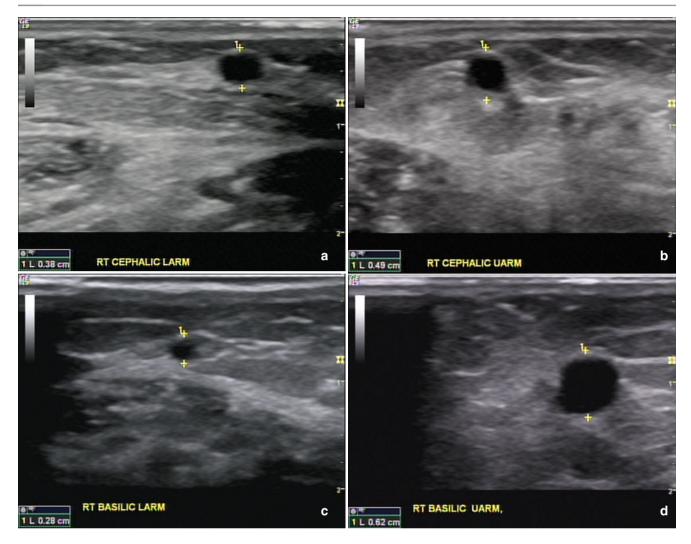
(a-d) Preoperative ultrasound images of the right cephalic and basilic vein in the upper and lower arm
